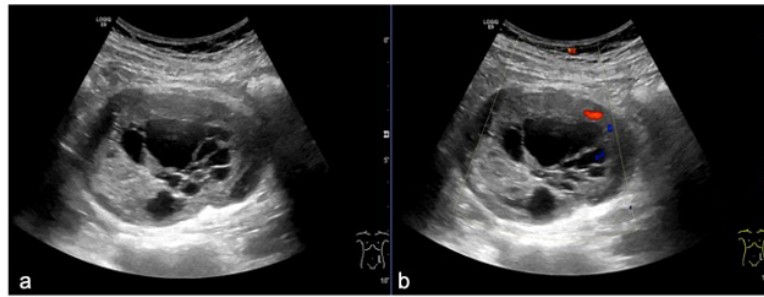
Gray scale US (a) and colour Doppler over the left flank area (b).
